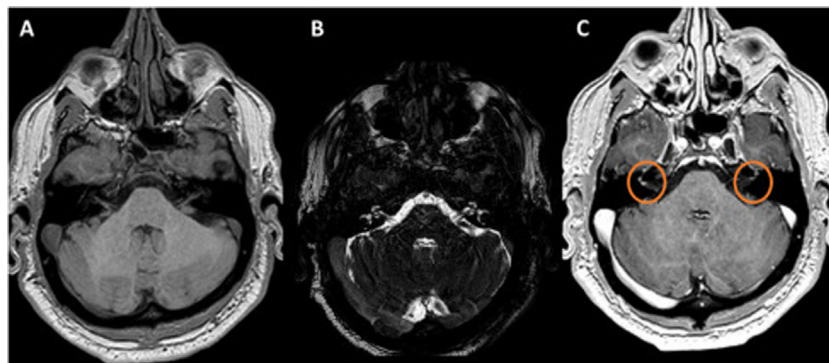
Brain MRI. (A) T1-weighted sequence. (B) Fat suppression T2-weighted sequence. (C) T1-weighted sequence with gadolinium. The figure shows millimeter enhancement of both the VII and VIII cranial nerves.
